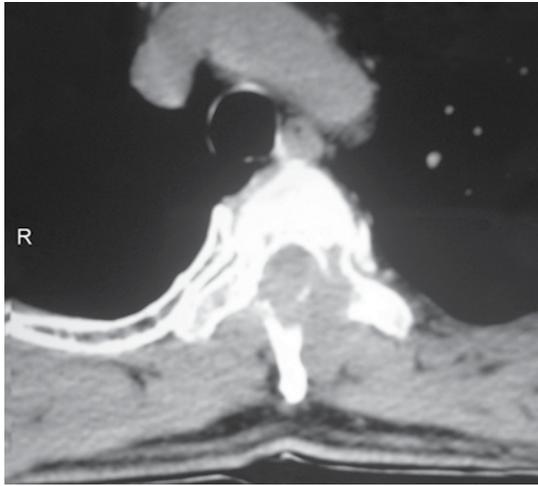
Computed tomography dorsolumbar spine showed lytic destruction of the spinous process, both laminae and left pedicle of the D3 vertebra
